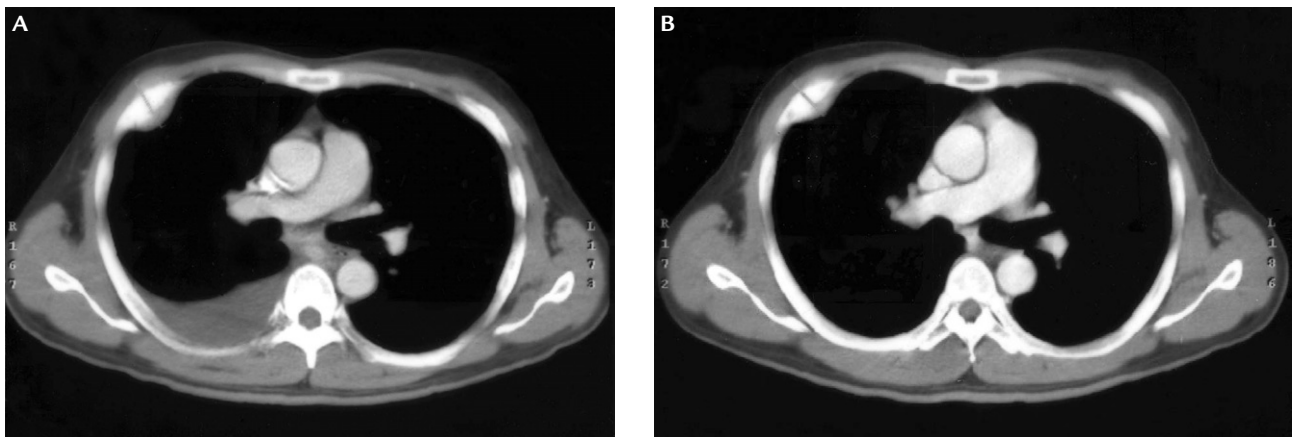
Computed tomography (CT) shows (A) development of right pleural effusion and increase in size of rib metastases compared to (B) CT 6 weeks prior, evident of progressive disease.
